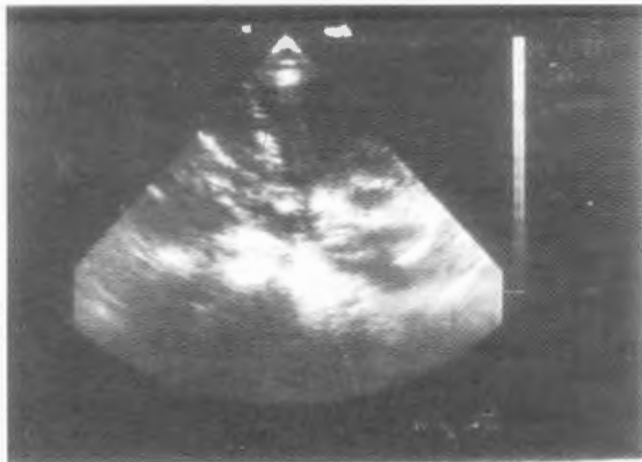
Ultrasound guided Amniocentesis : showing needle in amniotic cavity
